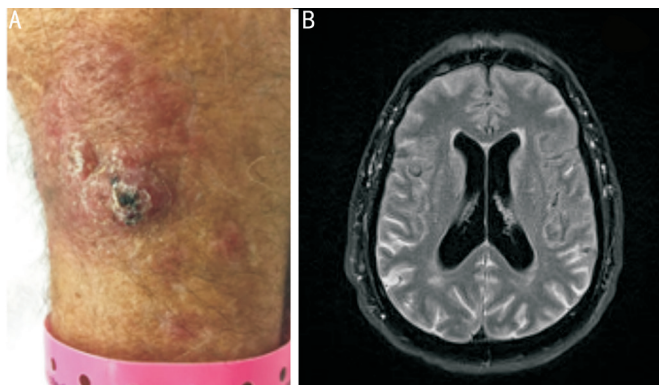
Skin and CNS manifestations A: Cutaneous cryptococcosis with nodules, maculopapules, and ulceration; B: Axial FLAIR MRI demonstrating diffuse lepto-meningeal enhancement and hydrocephalus.
